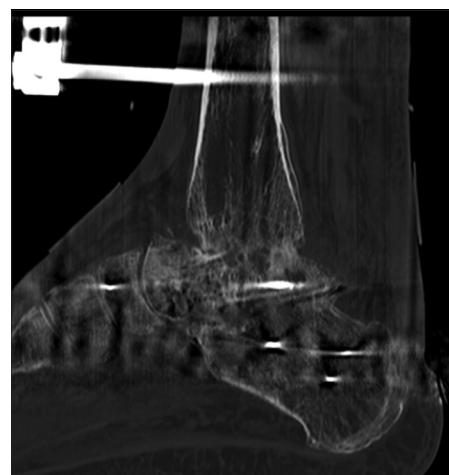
This sagittal computed tomography image was obtained while in the frame at the 10th-week follow-up appointment. It shows successful osseointegration at both the ankle and subtalar fusion sites. By scanning through all sagittal images in the series and assessing the amount of healing, a total of 70% healing was calculated
